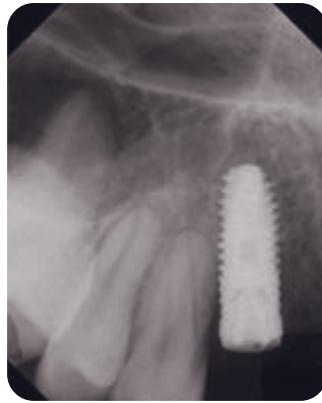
Radiograph of implant placed in maxillary right cuspid position.
